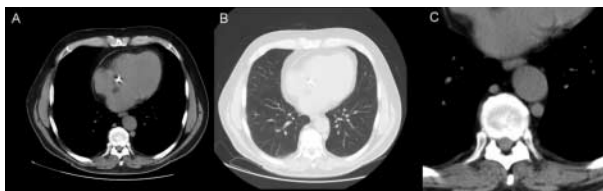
Contrast and brightness are manipulated to create "windows" which best accentuate specific structures. A. CT with "abdomen" window; B. CT with "lung" window; C. Magnification of vertebral body, with "abdomen" window.
